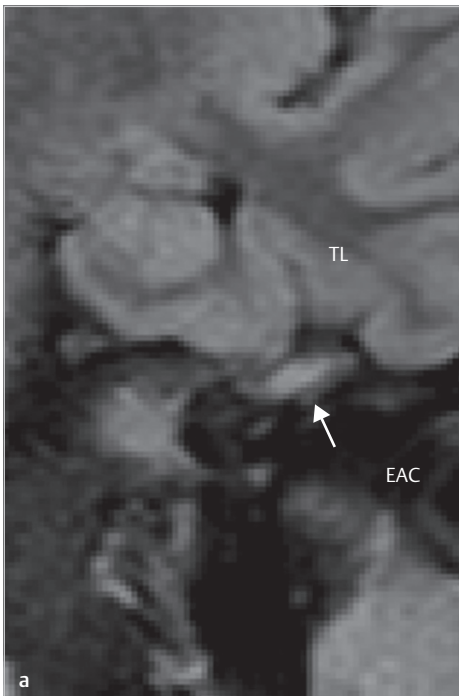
The coronal section of T1-weighted MRI (a) shows mid signal intensity under the temporal lobe, and the axial section of T2-weighted MRI (b) at the level of the lateral semicircular canal shows high signal intensity located laterally to the cochlea, corresponding to the presence of cholesteatoma (arrows). EAC, external auditory canal; IAC, internal auditory canal; LSC, lateral semicircular canal; TL, temporal lobe.
